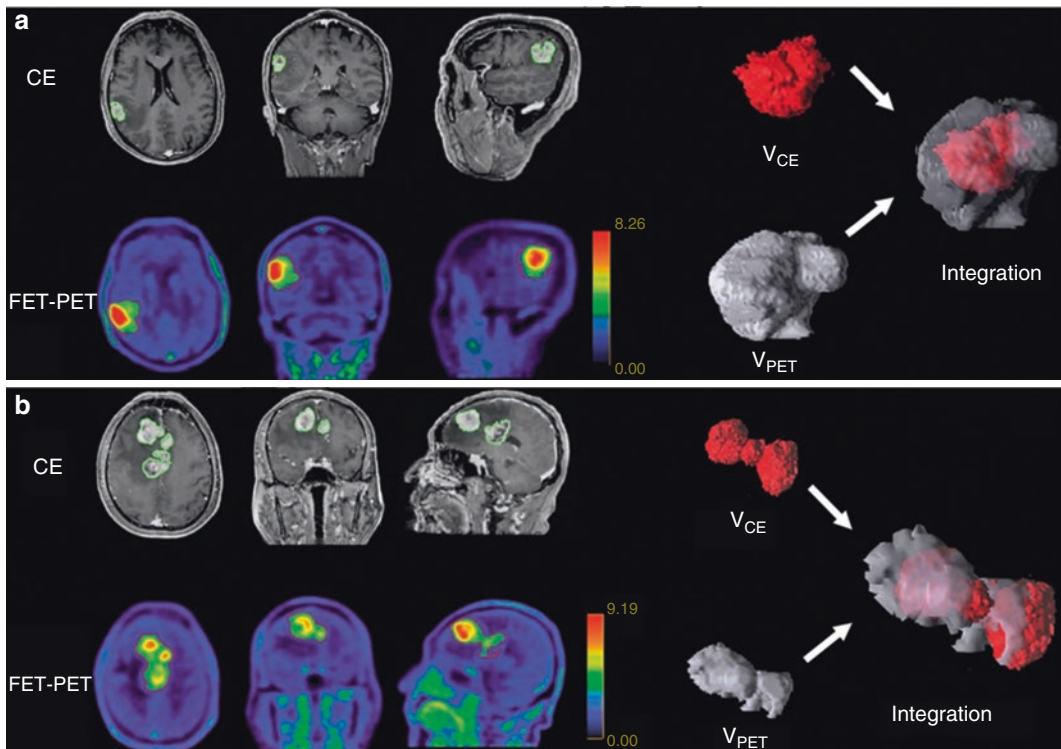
Integrated ^{18}F -FET PET/MR improves the presentation of glioma spatial distribution. ^{18}F -FET-PET and contrast-enhanced (CE) MRI show low spatial similarity but large overlaps. V_{PET} is significantly larger than
